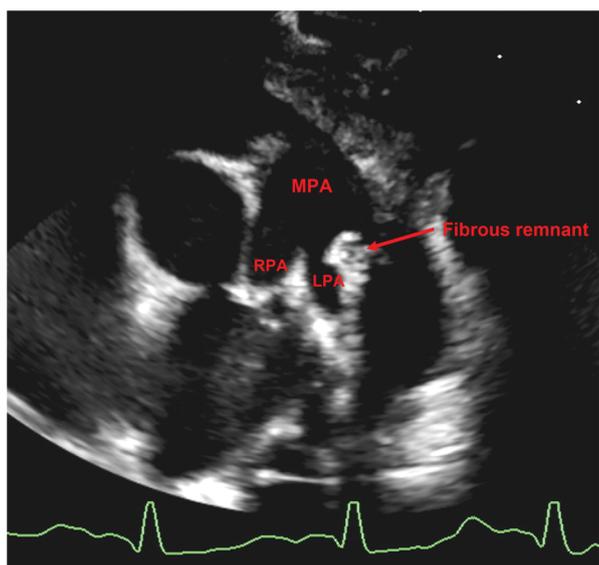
Echocardiogram demonstrating fibrous remnant in place of the ductus arteriosus, near the left pulmonary artery (LPA), right pulmonary artery (RPA), and main pulmonary artery (MPA).
